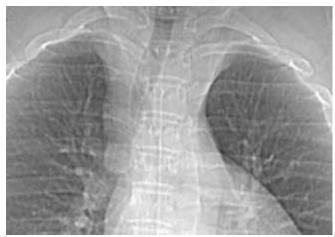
Chest X-ray showing a mass protruding into the tracheal lumen.
